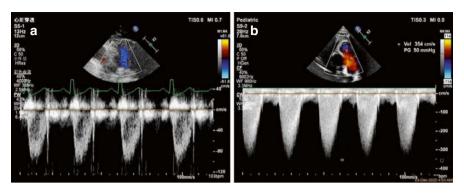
(a) Pulsed wave Doppler spectrum of a normal pulmonary valve orifice. (b) Continuous wave Doppler spectrum of pulmonary valvular stenosis
